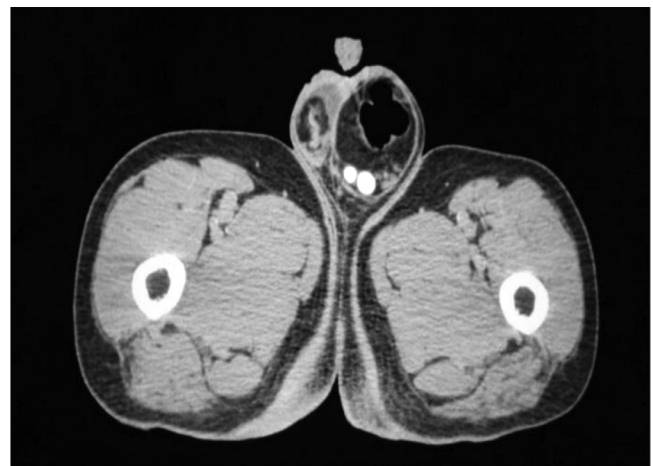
Axial Contrast-enhanced computed tomographic images showing efferent and afferent loops of the left ureter in the scrotum.
